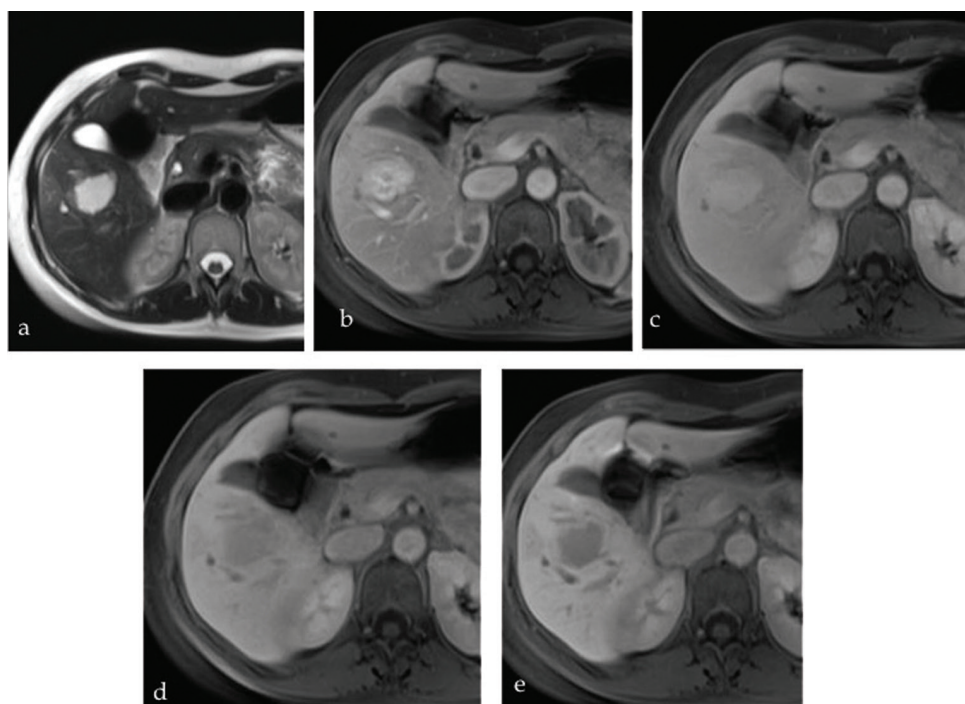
Haemangioma on hepatobiliary contrast. a. Intensely T2 bright lesion suggesting benign nature. b and c. Post contrast magnetic resonance imaging shows brisk enhancement with (d and e) apparent 'washout' from 5 to 15 minutes.
